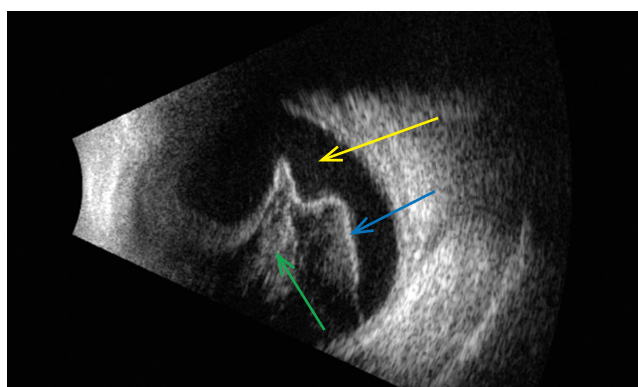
Ultrasound examination of the right eye: multiple inclusions were found, visualized as bodies, flakes (yellow arrow), strands and adhesions of various echogenicity (green arrow), non-fixated posterior detachment of the vitreous body (blue arrow).
